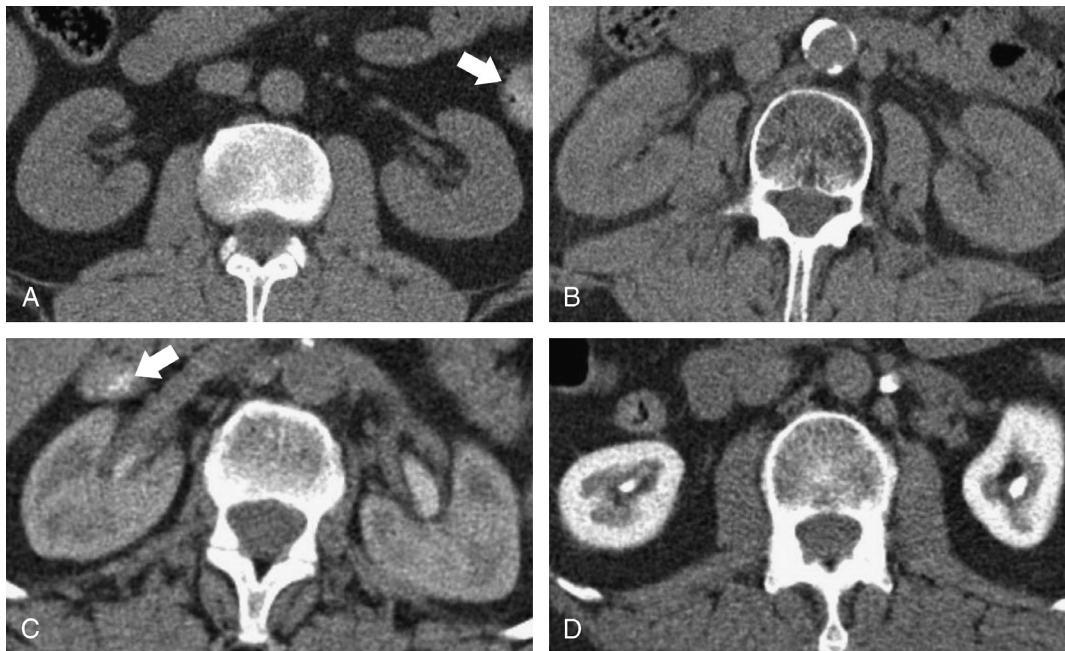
Axial unenhanced CT scans through the kidneys of 4 different patients 24 hours after CC. Kidneys were graded on the extent of persistent global nephrogram: (A) none, median cortical attenuation values 35.2 HU and 34.3 HU right and left kidneys, respectively; (B) faint, 64.9 HU and 61.8 HU right and left, respectively; (C) moderate, 91.8 HU and 93.6 HU right and left, respectively; and (D) marked, 156.4 HU and 163.3 HU right and left, respectively. Vicarious excretion of contrast in the small bowel is noted in the figures A and C (arrows).
